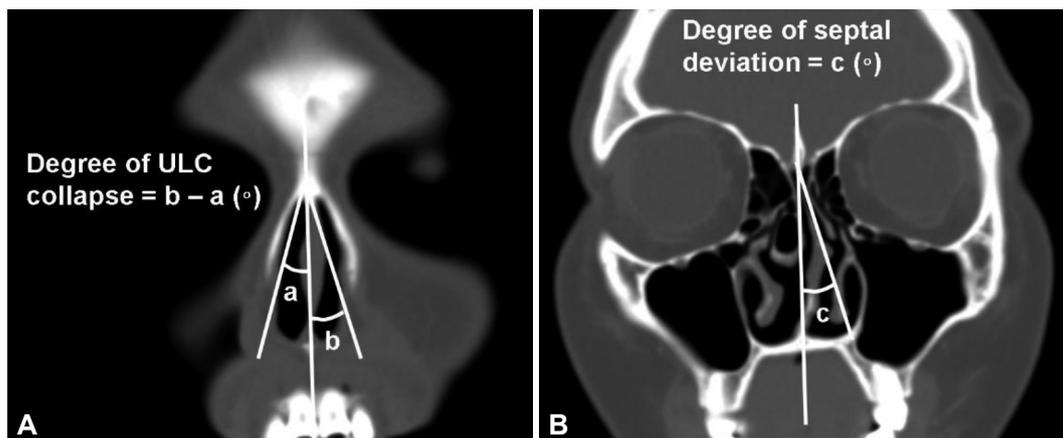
Coronal computed tomography (CT) image showing the technique for measuring the degree of upper lateral cartilage (ULC) collapse (A) and septal deviation (B). The midline of the face was set with the anterior nasal spine and crista galli as reference points, and then the left and right ULC angles were measured respectively. Based on these reference points, the degree of nasal septal deviation was also evaluated.
